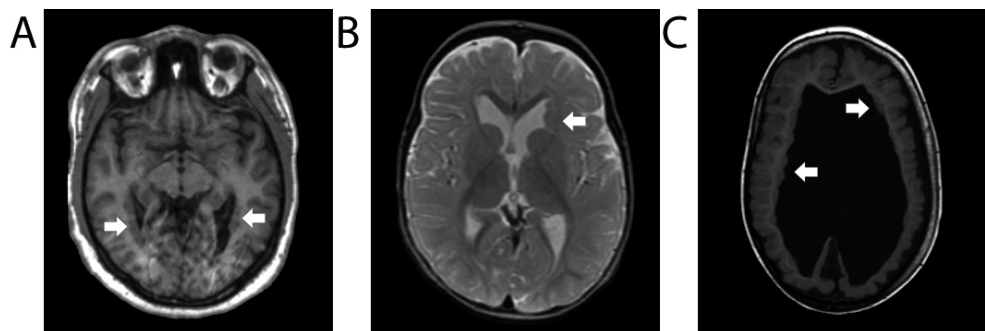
Brain MRI of all patients. A: Patient 1 at age 39 years, T1 weighted image. Note bilateral PNH in the occipital horns of the lateral ventricles (arrows). B: Patient 2 at age 11 months, T2 weighted image. Note a large PNH in the frontal horn of the left lateral ventricle (arrow). Ventricles are mildly enlarged for age. C: Patient 3 at age 3 years. T1 weighted image. Note bilateral PNH (arrows), hydrocephalus and diffuse polymicrogyria.
